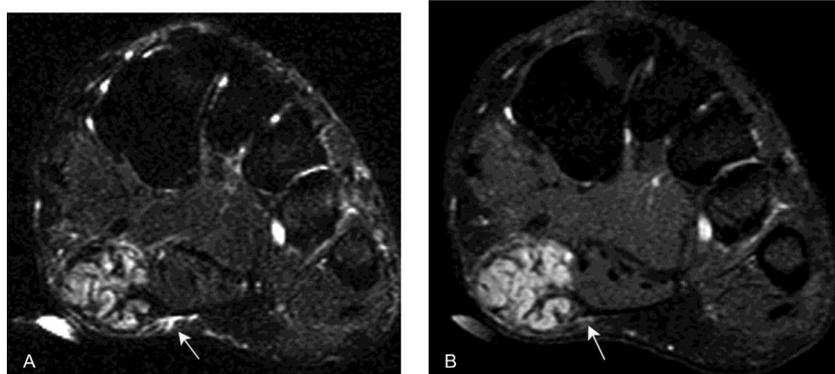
Plantar fibromatosis. (A) Coronal short-axis fat saturated T2WI shows a lobulated mass in the medial aspect of the foot. The mass is relatively high signal to muscle suggesting hypervascularity. (B) Coronal short-axis postcontrast fat saturated T1WI shows homogeneous intense enhancement. The characteristic "fascial tail" sign is seen in both images (white arrows in A and B). T1WI, T1-weighted images; T2WI, T2-weighted images.
